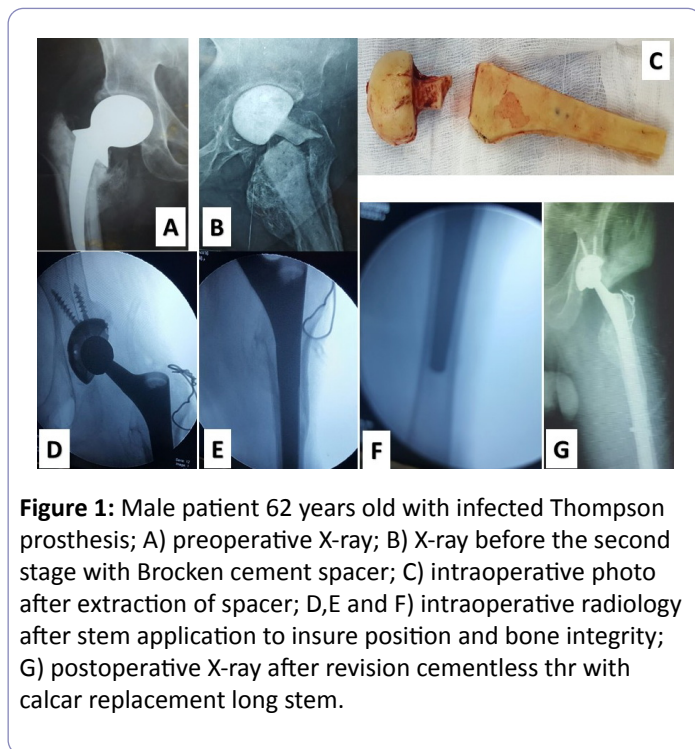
Male patient 62 years old with infected Thompson prosthesis; A) preoperative X-ray; B) X-ray before the second stage with Broken cement spacer; C) intraoperative photo after extraction of spacer; D,E and F) intraoperative radiology after stem application to insure position and bone integrity; G) postoperative X-ray after revision cementless thr with calcar replacement long stem.
